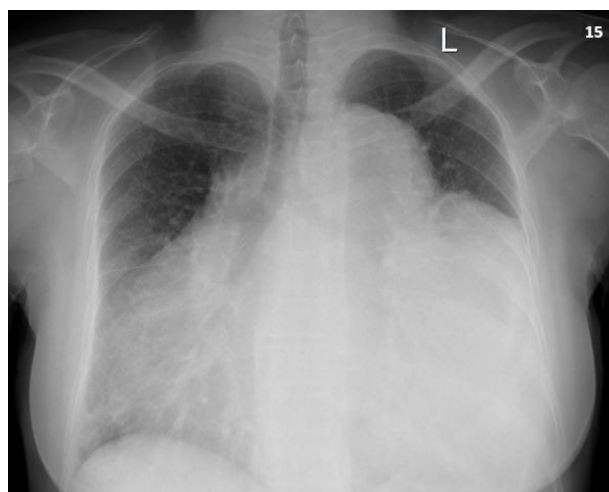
Case 4. Anteroposterior chest radiograph pericardial effusion
